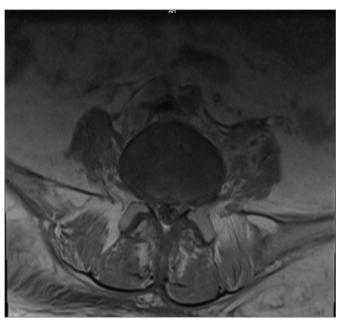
Small circumferential contrasting abscess formations in the left psoas muscle on lumbar MRI
